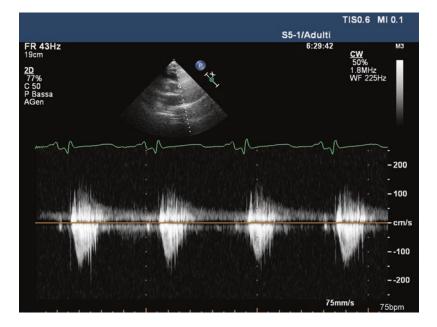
TTE parasternal short-axis view, pulmonary artery VTI: short acceleration time in pulmonary hypertension
